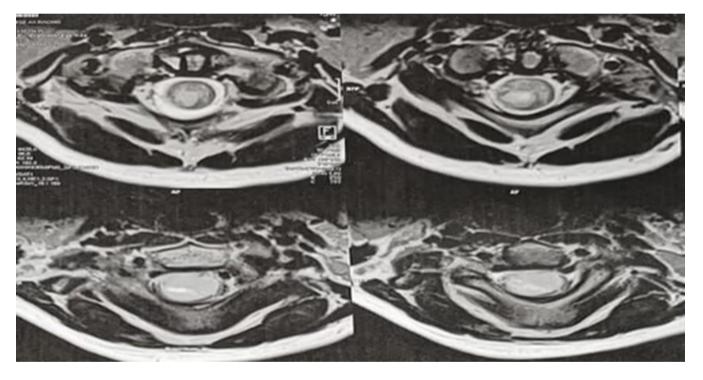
Cervical MRI, axial T2-weighted sequence showing an intramedullary hyperintense lesion predominantly lateralized to the right.
